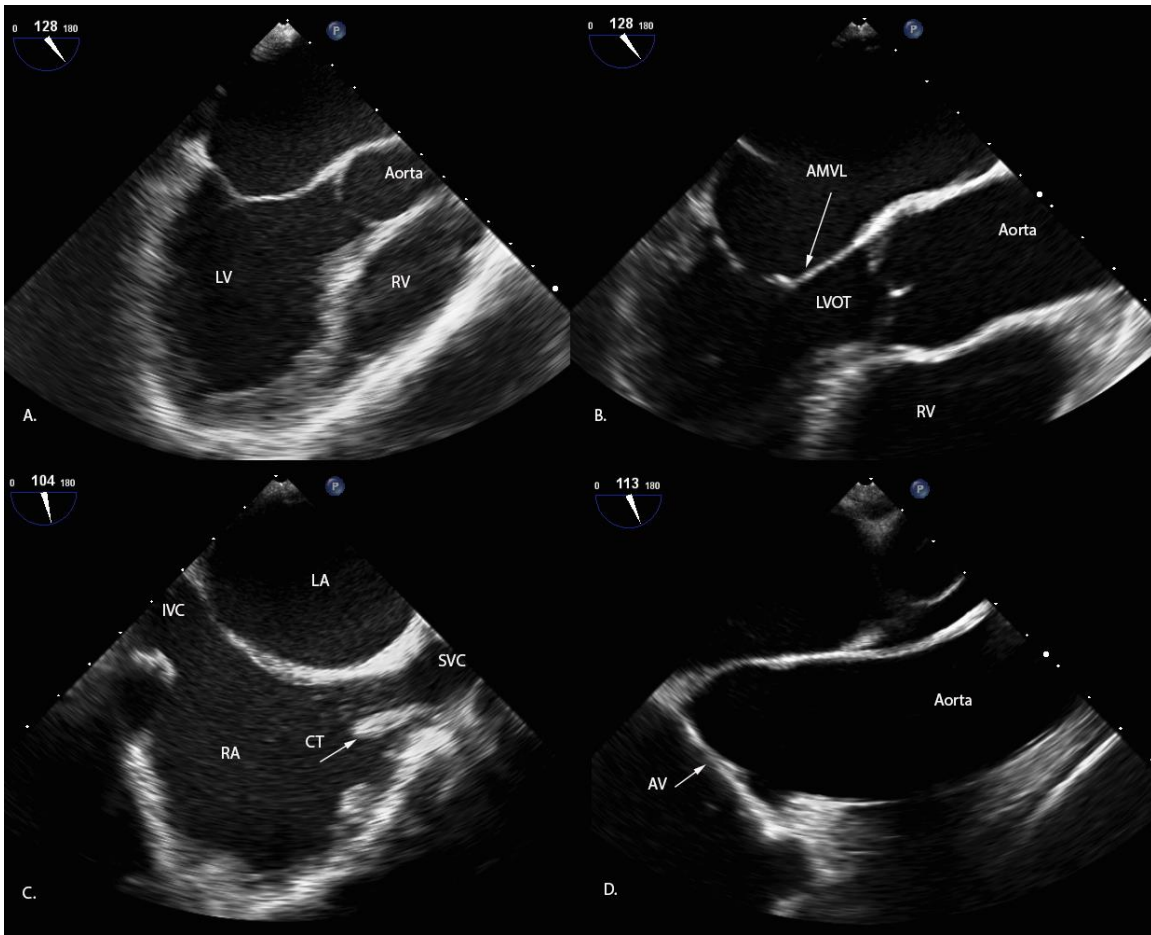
Left ventricular long axis, proximal aorta, and bicaval views. [View 5] Mid-esophageal left ventricular long axis view, Panel A: the LV and aortic valve are seen, with a portion of the RV in the far field, towards the right side of the image. [View 6] Mid-esophageal aortic valve long-axis view, Panel B: the anterior mitral valve leaflet (AMVL) is adjacent to the posterior aspect of the aortic valve; this is obtained by decreasing the depth from the LV long axis view and rotating the probe slightly so the aortic valve is in the center of the sector. [View 13], Panel D: upper-esophageal ascending aorta long-axis view. [View 11] Mid-esophageal bicaval view, Panel C: the LA is in the near field with the inter-atrial septum bisecting the imaging sector. The superior vena cava (SVC) drains on the right side of the display. Adjacent to the SVC is the crista terminalis (CT).
